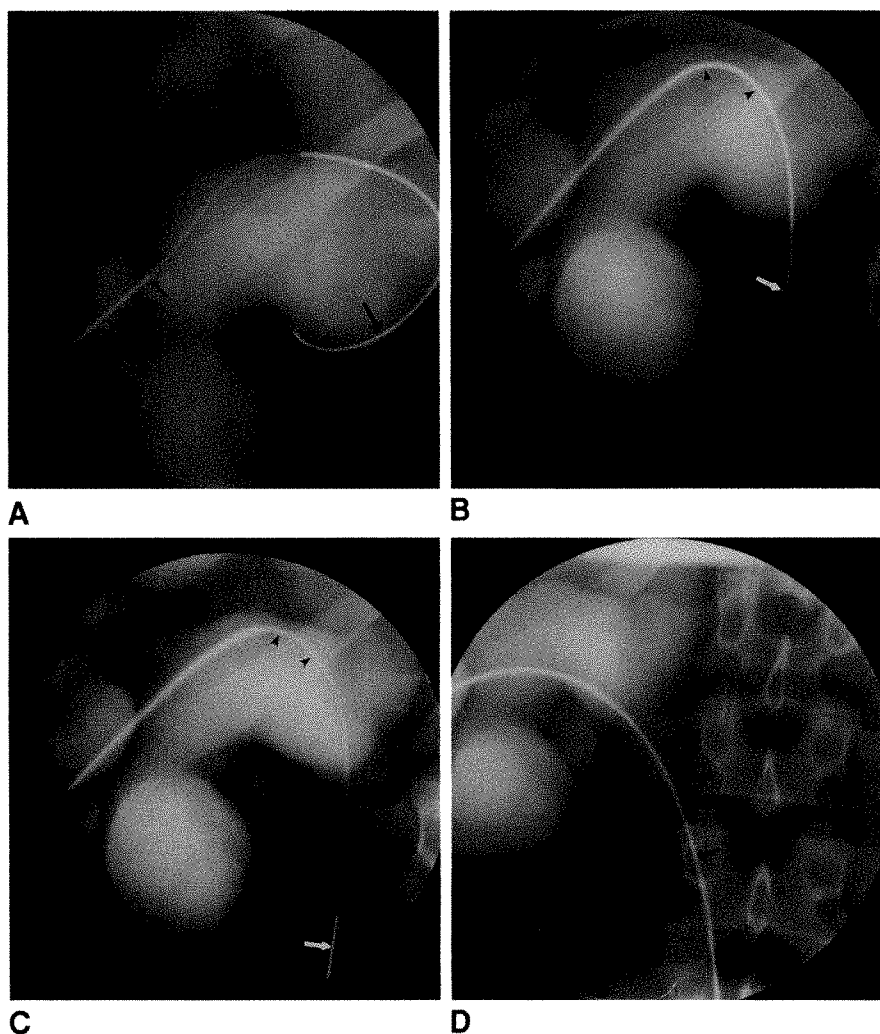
A, Spot radiograph shows a 21-gauge needle tip (small arrow) and proximal portion of a Cope wire (large arrow) within dilated renal pelvis. Note ureteropelvic junction (UPJ) strictures (arrowheads).
